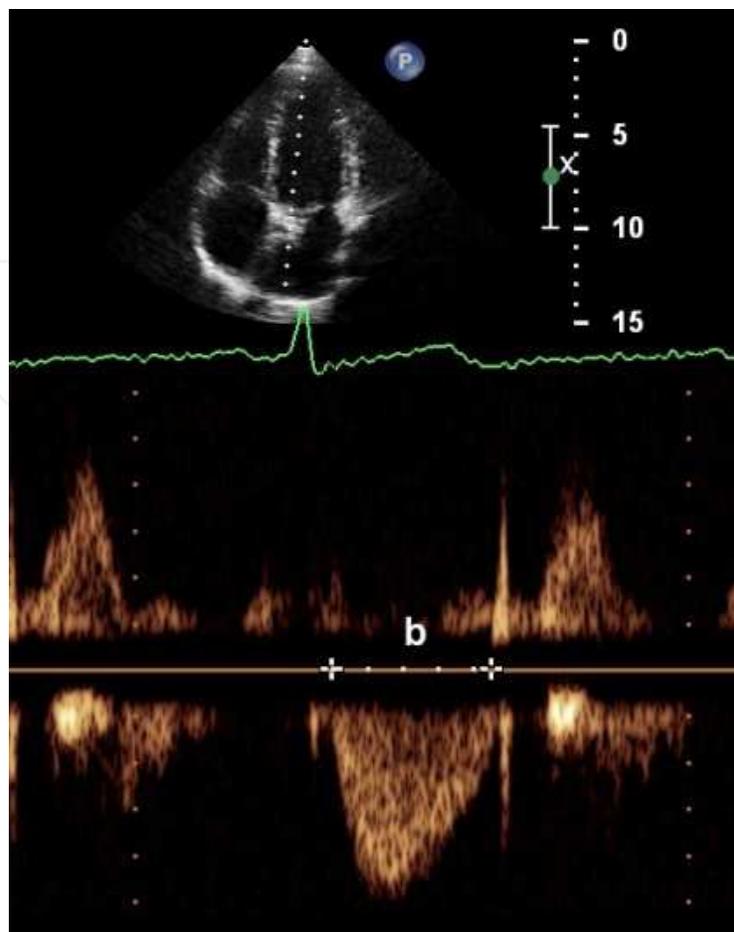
Measurement of interval (b) which represents the ejection time. The spectrogram is registered with PW-Doppler in the left ventricular outflow tract from apical 5-chamber view.
